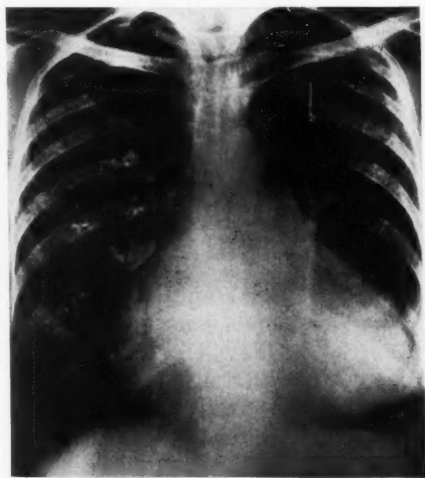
Posteroanterior roentgenogram of the chest of a 43 year-old female with severe mitral stenosis, tricuspid insufficiency, auricular fibrillation, hepatomegaly, previous right-sided failure and orthopnea. Right atrium and right ventricle are markedly enlarged. Note right border of large left atrium within right atrial shadow.
